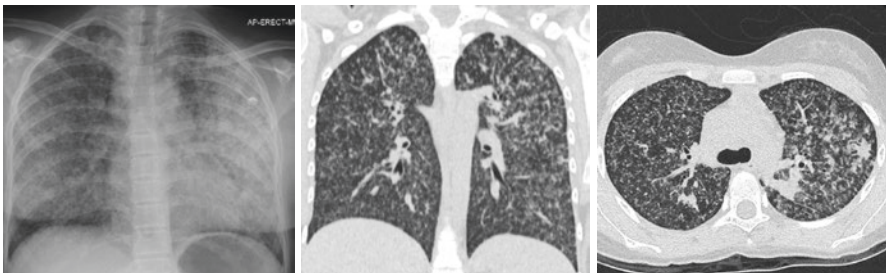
CXR and CT appearance of miliary TB
